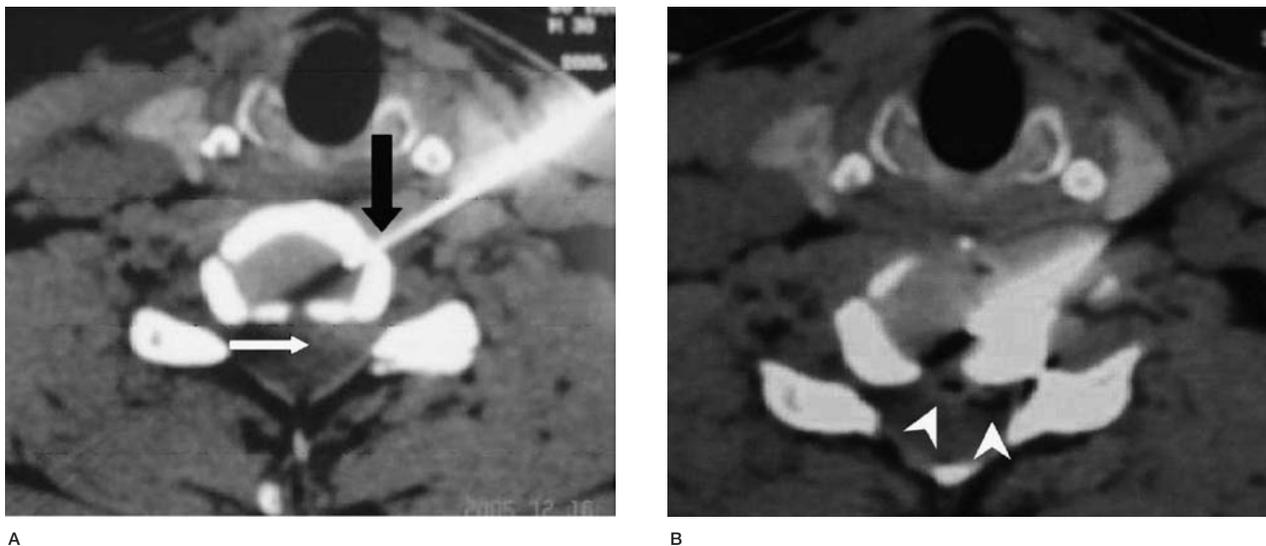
Images in a patient with C6-C7 left paramidline disk herniation (radiculopathic type). A) Precontrast CT image at the C6-C7 level shows left posterolateral disk herniation with left nerve root compression (*white arrow*); the needle was introduced into disk (*black arrow*) through a left anterolateral approach before ozone injection. B) After pushing ahead the needle 5 mm and injection of 3 ml 60 ug/ml ozone, CT shows ozone dispersion into the herniated disk material (*white arrowheads*).
